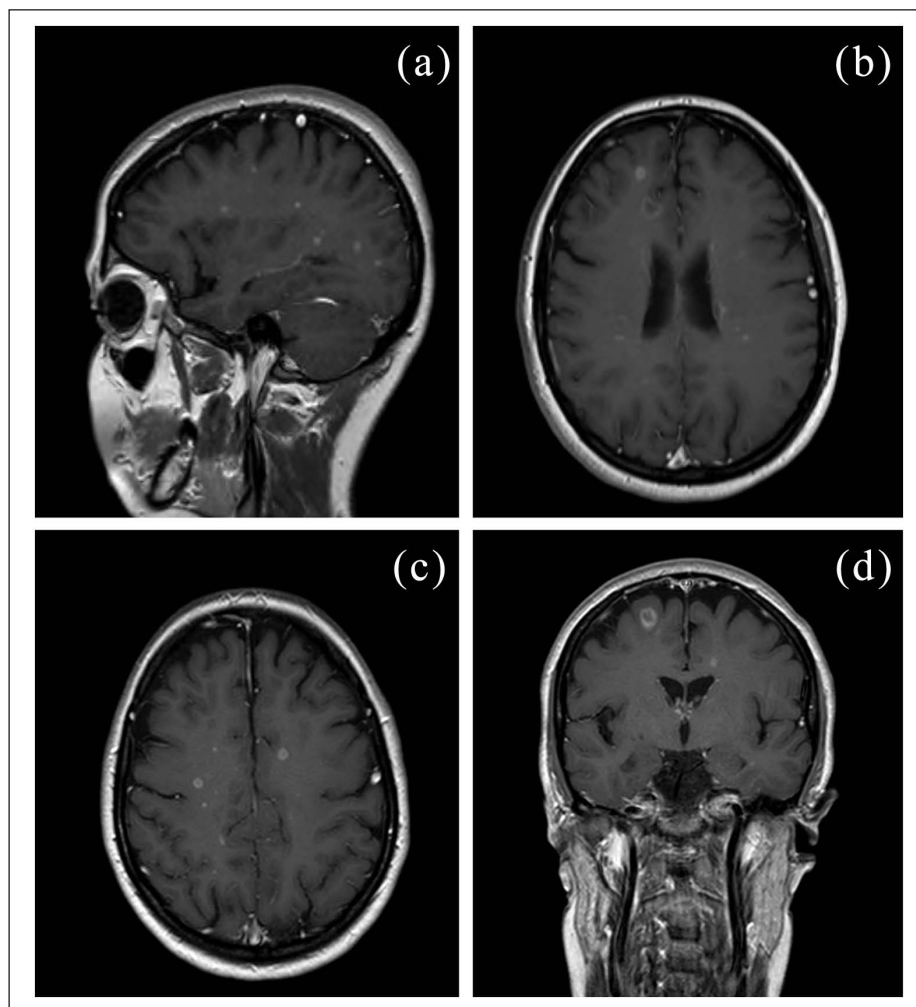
T1-weighted/gadolinium-enhanced lesions on sagittal and axial MR images performed after natalizumab discontinuation in May 2008 (a), (b). T1-weighted/gadolinium-enhanced lesions on axial and coronal MR images performed after natalizumab discontinuation in April 2010 (c), (d).
